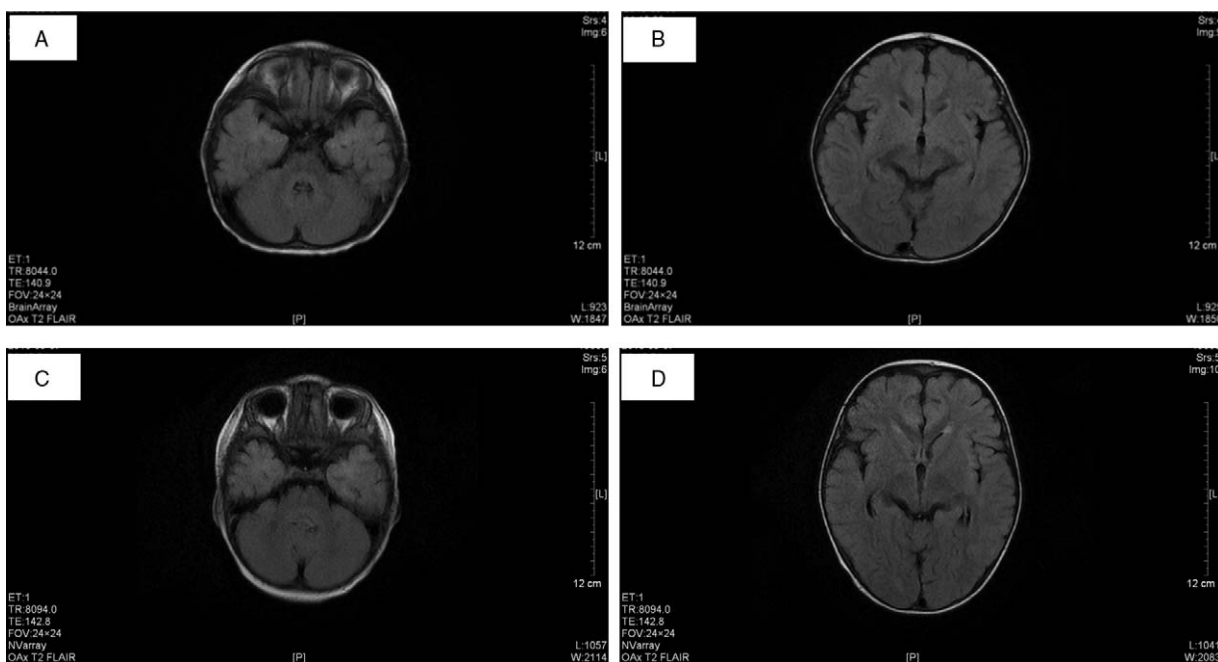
Head magnetic resonance imaging of the patients after treatment. T2 FLAIR signal in the right cerebellar hemisphere (A) and in the bilateral occipital lobe (B) of patient 1 on day 30 after treatment. T2 FLAIR signal in the right cerebellar hemisphere (C) and in the bilateral occipital lobe (D) of patient 2 on day 30 after treatment.
